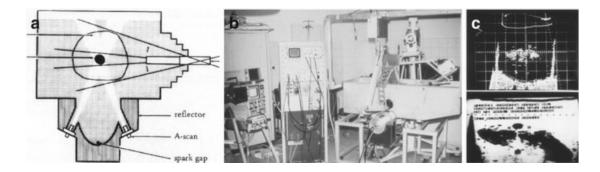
(a) Integration of ultrasound scanners. (b) Experimental lithotripter with integrated ultrasound scanners. (c) Transverse sonogram after stone implantation
